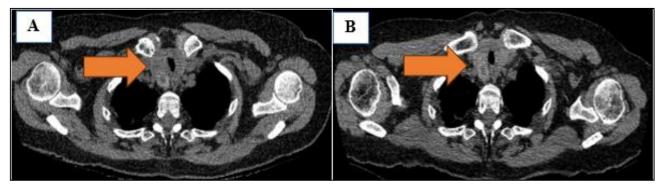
Panel A: CT scan from July 2023, Panel B: CT scan from October 2023 after treatment with ICS/LABA for 1 month
